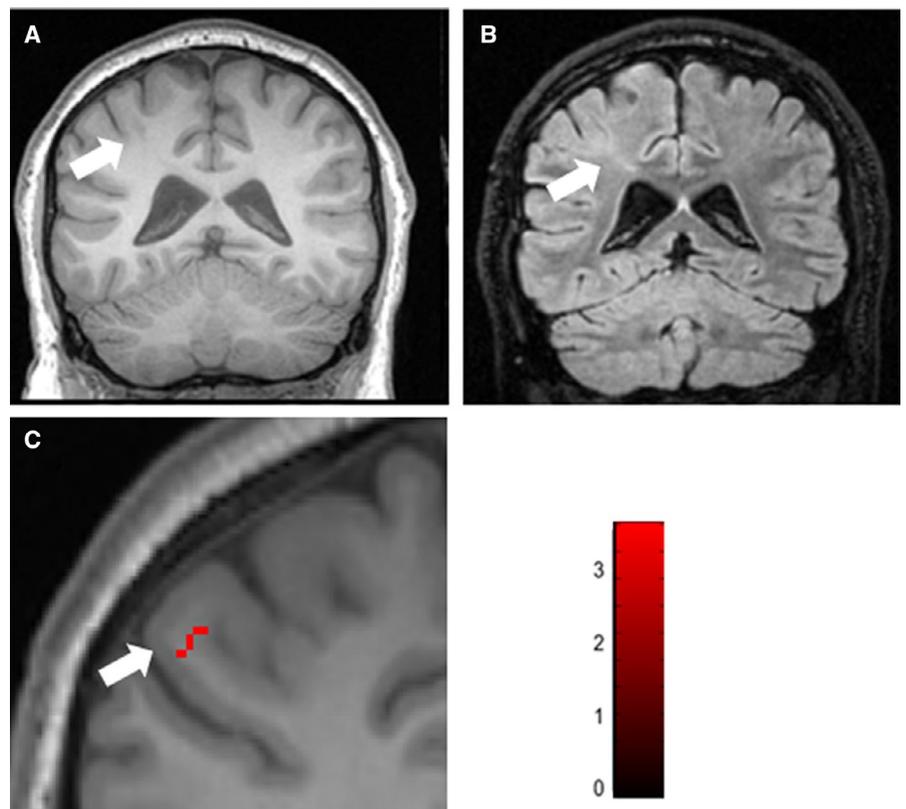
Patient 2: Attenuated increase after P-gp inhibition. The area of the presumed FCD in the left posterior central gyrus seen as decreased signal on T1-MRI with cortical thickening and blurring of the gray-white matter junction (A) and as signal hyperintensity on the FLAIR-MRI image (B). Maximum of attenuated increase in VPM- K_1 after P-gp inhibition with TQD in the area of the FCD (left posterior central gyrus) compared to 12 healthy controls indicating focal increases in P-gp in the area of the FCD (C). Significant clusters $P < .001$ are overlaid onto the individual patient MRI
